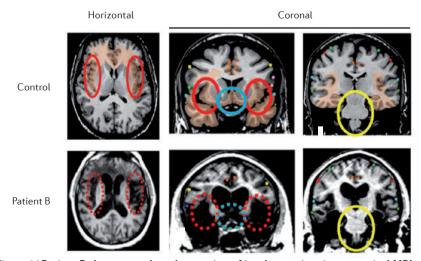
Patient B shows complete destruction of insular cortices in anatomical MRI scans. Top row, control; bottom row, patient B. Red circles mark the insula; yellow circles mark the brainstem; blue circles mark the basal forebrain region. Data from REF. 114. Image courtesy of H. Damasio, University of Southern California, USA.
